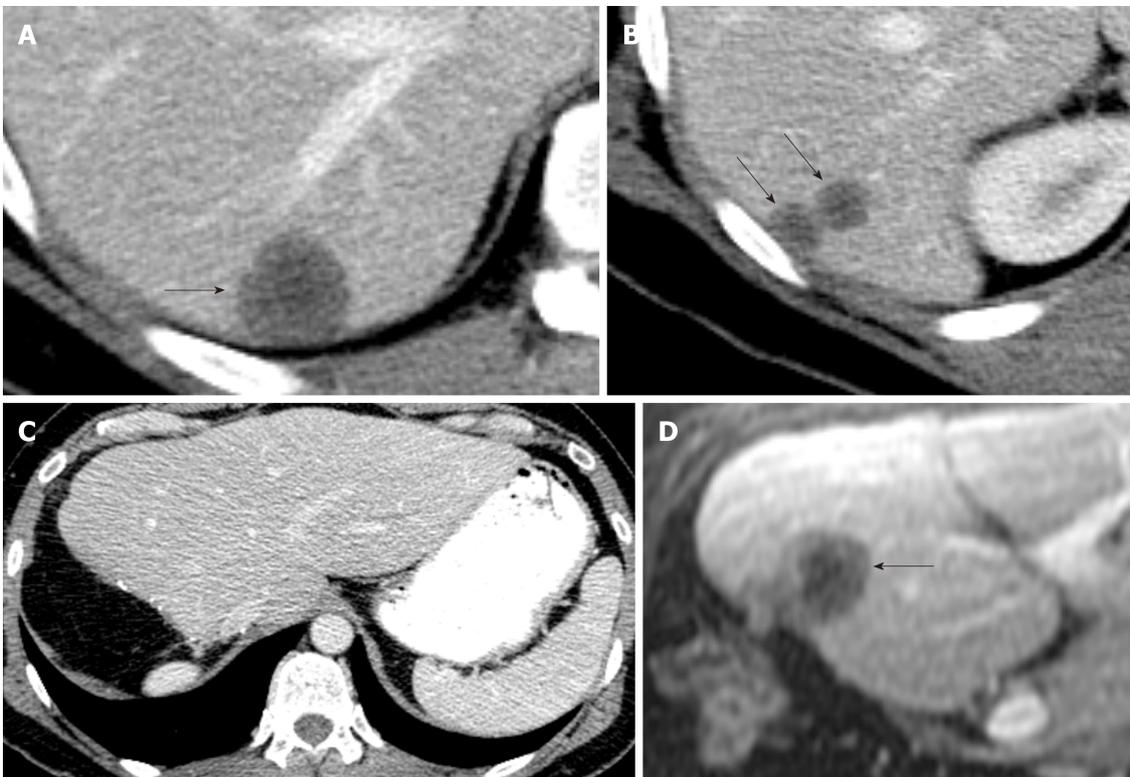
Recurrent hepatic hemangioepithelioma. A and B: Axial contrast enhanced CT images show hepatic hemangioepithelioma nodules (arrows); C: Axial contrast enhanced CT image shows post-surgical changes related to right hepatectomy; D: 3 mo follow up axial post contrast T1 Weighted Image Magnetic Resonance Imaging image shows a recurrent hepatic hemangioepithelioma (arrow).
